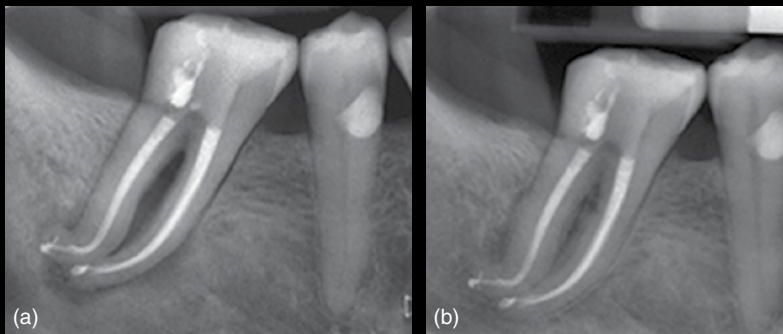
(a) Final radiograph. (b) 12-month recall.
